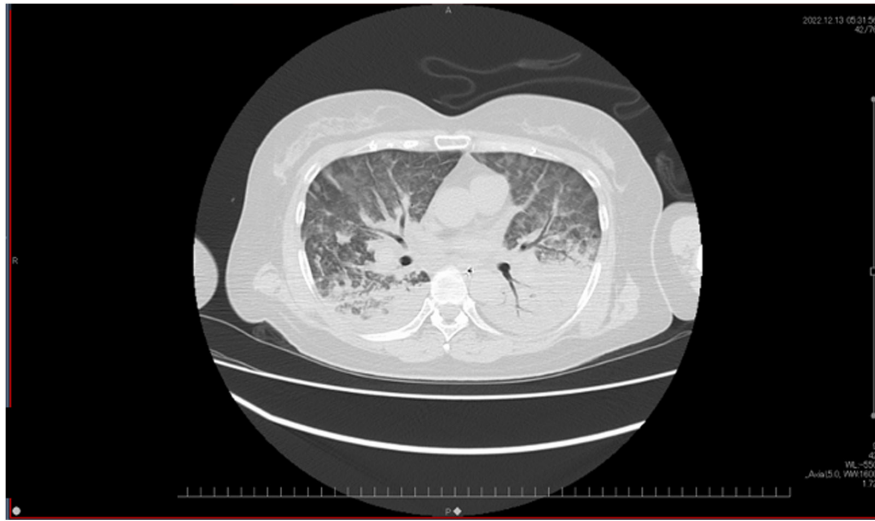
The CT scan of the chest of the patient on the initial visit.
